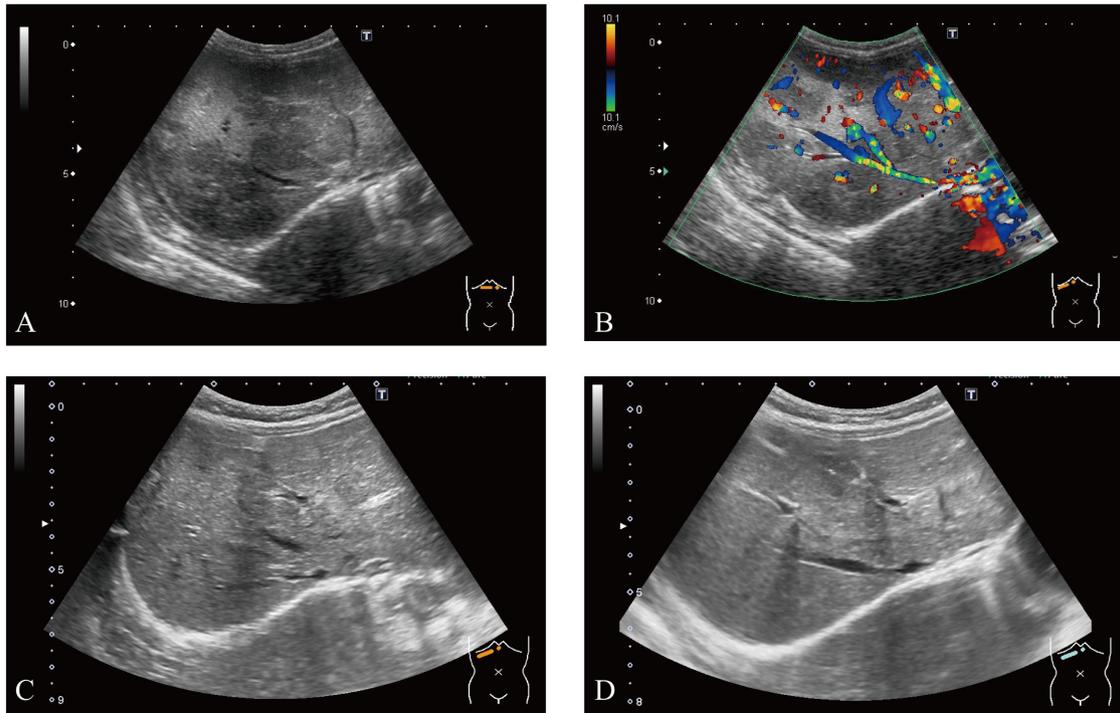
Pretreatment abdominal ultrasonography showed multiple round low echoic lesions in the right hepatic lobe at the age of 2 months (A). Doppler study showed vessels surrounding the nodules at the age of 2 months (B). After starting propranolol, abdominal ultrasonography at the age of 3 months showed marked involution (C). Abdominal ultrasonography revealed no tumor in the liver at the age of 5 months (D).
